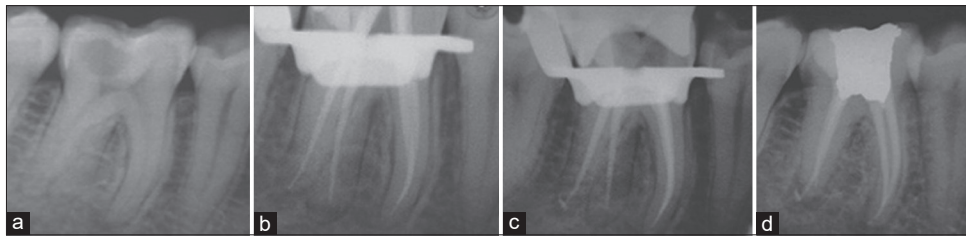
(a) Preoperative radiograph (b) working length (c) master cone radiograph (d) obturation and post endodontic restoration
